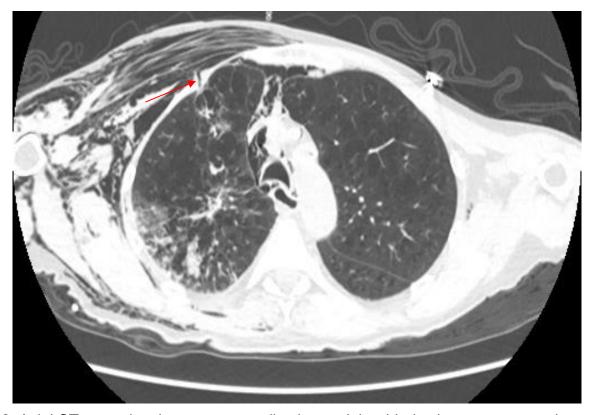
Axial CT scan showing pneumomediastinum, right-sided subcutaneous emphysema, and a partially opacified tubular tract extending from the right-upper lobe mass to the anterior chest wall, consistent with a bronchopleural-subcutaneous fistula [arrow].
